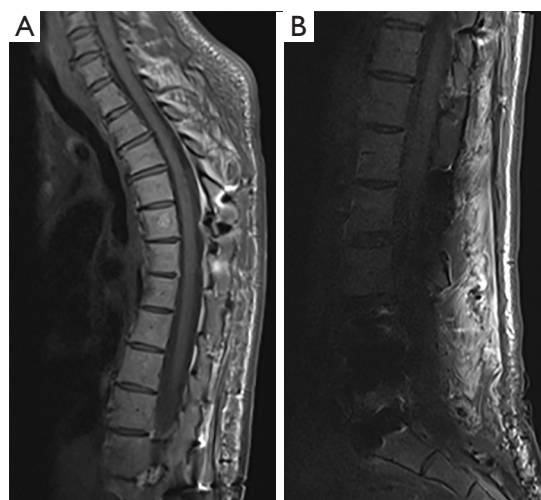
Postoperative spinal magnetic resonance imaging. (A) Cervical/thoracic and (B) lumbar spine magnetic resonance imaging obtained immediately postoperatively, demonstrating no acute cord compression/spinal canal complication or hematoma within the limits of extensive hardware artifact.
